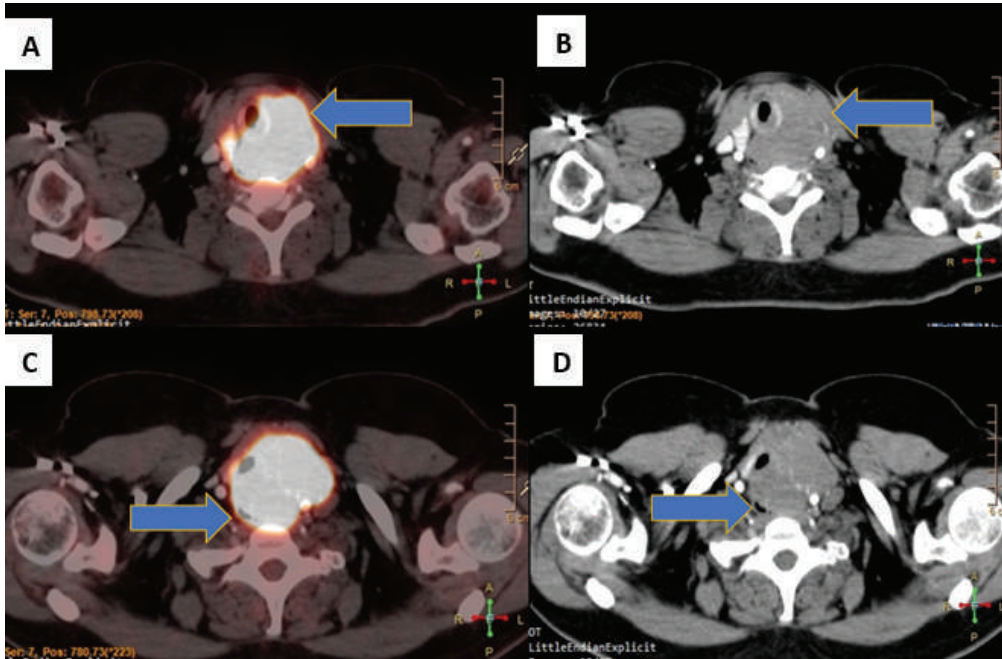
Baseline ¹⁸F-FDG PET-CT fused axial images showing a large lobulated hypermetabolic soft tissue mass involving the left lobe of the thyroid gland with extensive local invasion and involvement of the epiglottis, vocal cords (A, B), proximal trachea, and erosion of the thyroid and cricoid cartilage (C, D).
